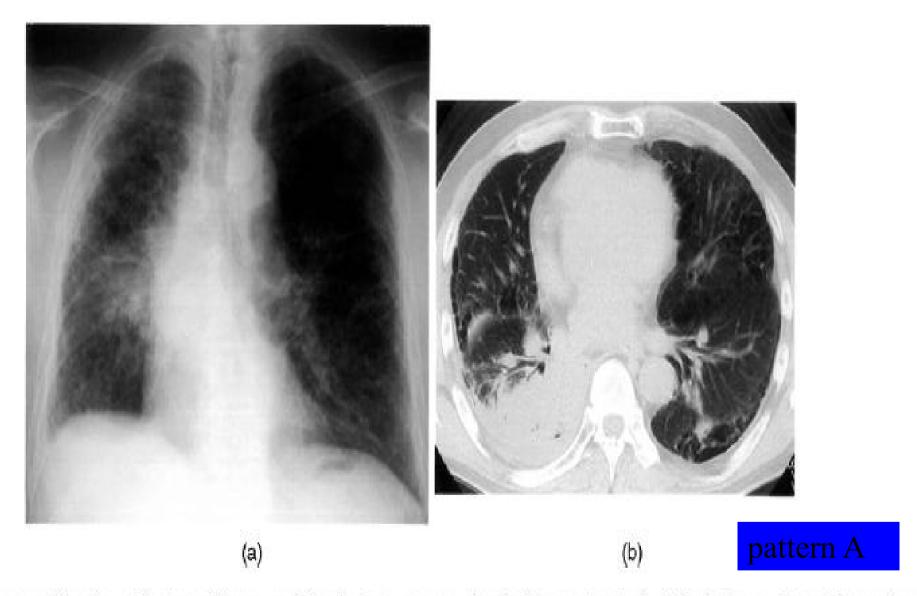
A 60-year-old male with stage IV non-small cell lung cancer who had been treated with platinum-based chemotherapy developed mild dyspnea on day 10 after administration of gefitinib. The chest radiography reveals a mass opacity in the right hilum and diffuse ground-glass density over the entire lung field against a background of emphysema and fibrosis (a). The CT scan shows nonspecific areas with ground-glass attenuation throughout the lung parenchyma (b).
